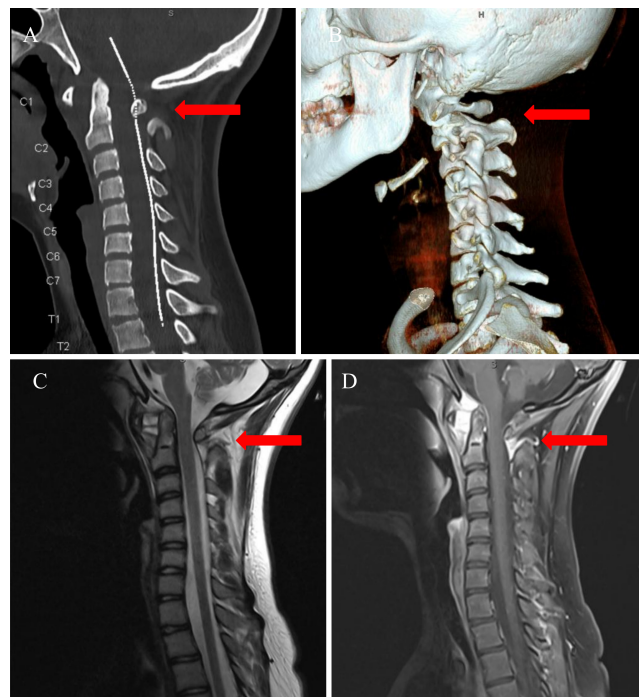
Abnormal widening of the C1–2 joint space with anterior displacement of C1 relative to C2, measuring 10 mm (red arrows in panels A and B), resulting in mild narrowing of the thecal sac to 8 mm anteroposteriorly in the supine position. A: Sagittal cervical spine soft tissue image. B: Sagittal 3D anatomical reconstruction. No associated fracture is observed. C and D: T2-weighted (C) and T1-weighted (D) cervical spine images revealing abnormal widening of the anterior C1–2 interval, along with posterior displacement of the dens relative to C1 and the skull base. This led to mild thecal sac narrowing and near-complete effacement of the CSF (red arrows). The abnormal soft tissue within the C1–2 space exhibits postcontrast enhancement and T2 hyperintensity, suggestive of inflammatory soft tissue, with a differential diagnosis including pannus related to JIA.
